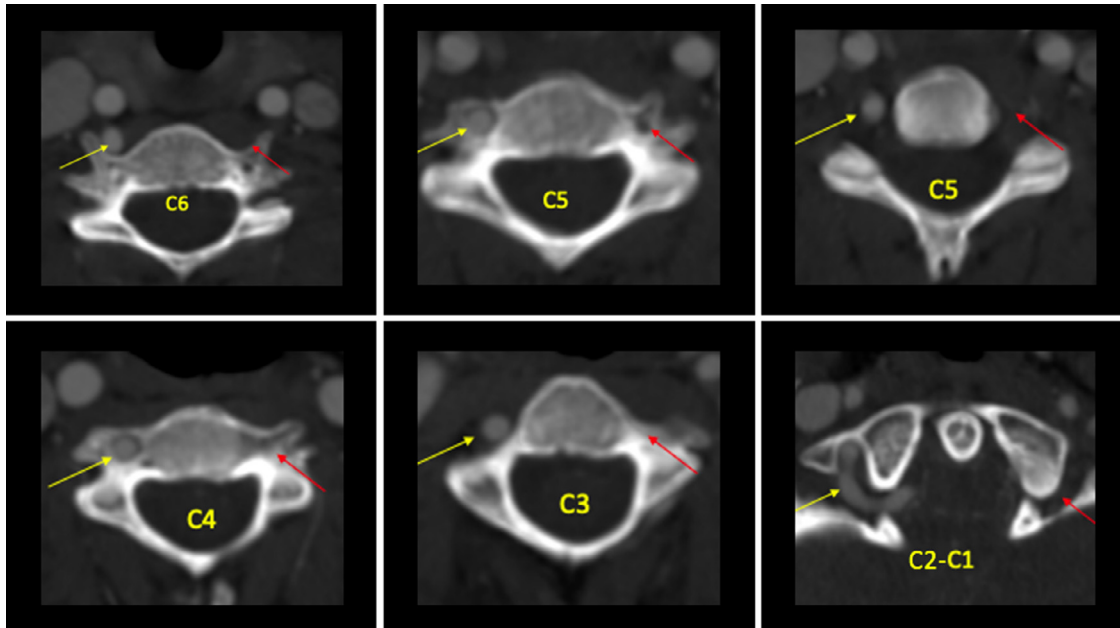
Caudocephalic axial sequences of a neck CT angiography from the C6 to C1 vertebrae. The yellow arrow represents the course of the right vertebral artery until it reaches the base of the skull. The red arrow represents the absence of the left vertebral artery and the agenesis of the transverse foramen throughout its course.
